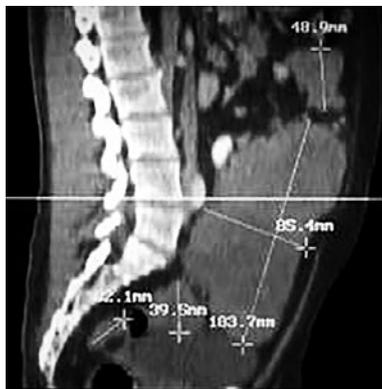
Computed tomography of the abdomen. Presence of intra-expansive abdominal lesion and multiple implants.
